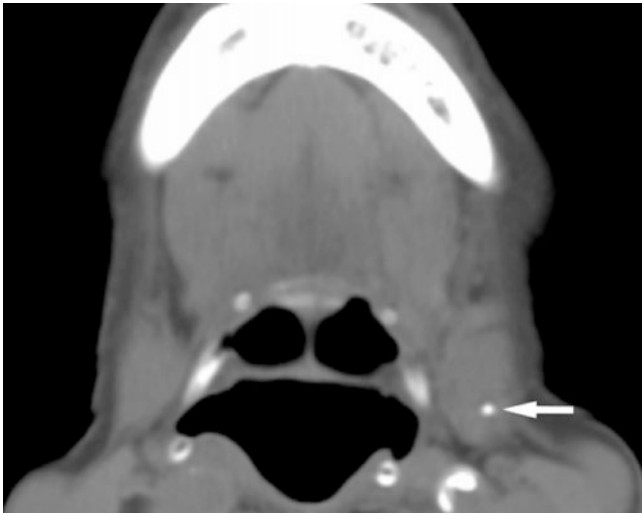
Submandibular gland stone; 86-year-old female with submandibular pain. Axial post-contrast CT image shows small stone in the hilum of submandibular gland (*arrow*)
